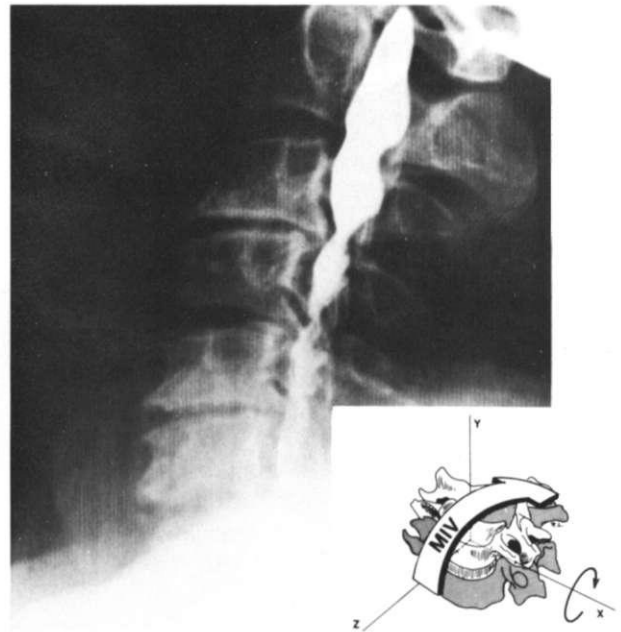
Radiograph of a 50-year-old male with cervical spondylosis who suddenly became paraplegic following a moderate fall off of a curb due to intoxication. The patient struck his head and extended his neck at the time of the fall. The cord damage here is due to the encroachment of the spinal cord at the C4–C5 level by midline osteophytes anteriorly and invaginated ligamentum flavum posteriorly, both shown by the partial block on myelogram. A radiologic estimate of the true sagittal anteroposterior diameter of the spinal canal in this patient is only 6 mm at the C4–C5 level. This is an example of minor trauma or possibly even a physiologic motion causing damage when the margin of safety and space for the cord has been significantly reduced. (Courtesy of Teaching Library, Section of Neuroradiology, Yale University School of Medicine.)
